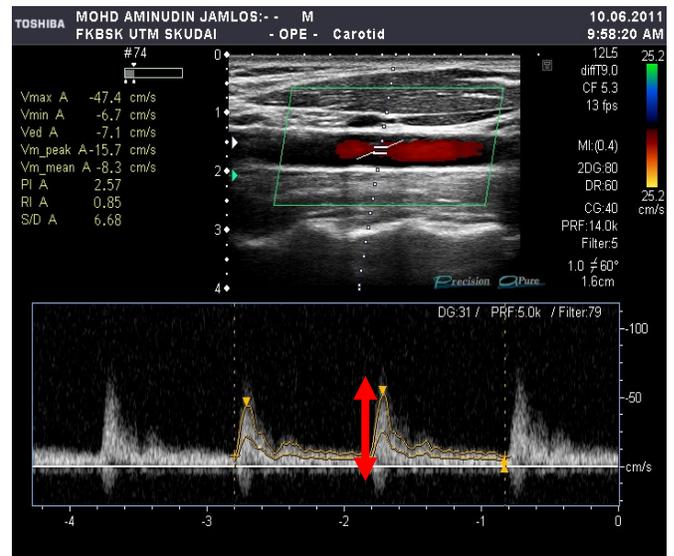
Normal (rest) Doppler carotid artery image
